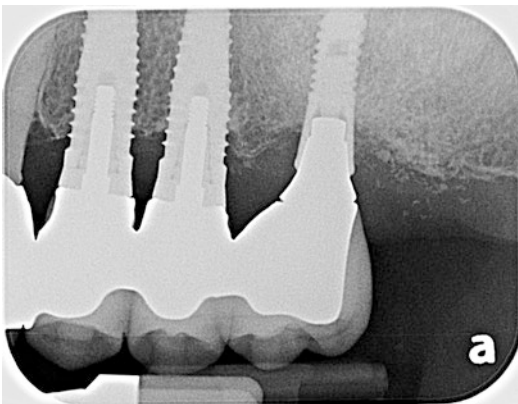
Pretreatment radiograph suggests early to moderate bone loss around the dental implants. A gap appears in the crown-abutment interface of the posterior implant
